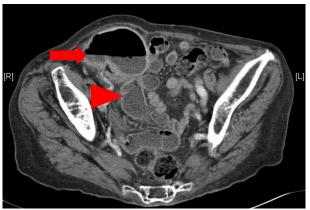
Axial computed tomogram of the abdomen showing a dilated caecum with an air fluid level (red arrow) and mildly dilated fluid filled terminal ileum (red arrowhead)
